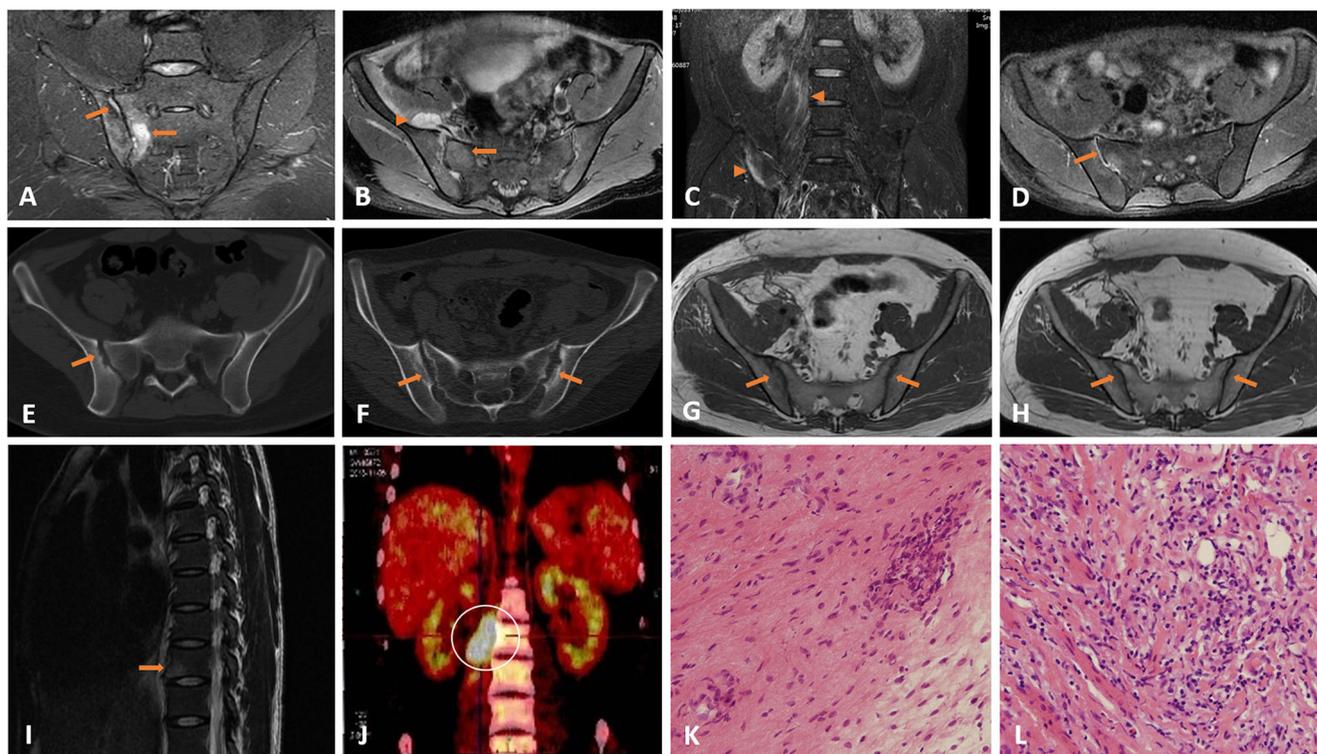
Imaging and pathological examinations of brucellosis patients. a Heterogeneous hyperintense signal (arrow) in T2-weighted image with fat saturation indicating bone marrow edema in sacroiliac joints. b, c Involvements of sacroiliac joints (arrow) and adjacent muscles (arrow head) detected in axial (b) or coronal (c) T2-weighted images with fat saturation. d Synovitis in right sacroiliac joint in axial T2-weighted image with fat saturation. e, f Bone erosions on the articular surfaces in axial sacroiliac joint CT images indicating unilateral (e) or bilateral (f) sacroiliitis. g, h Axial T1-weighted images of one brucellosis patient.
